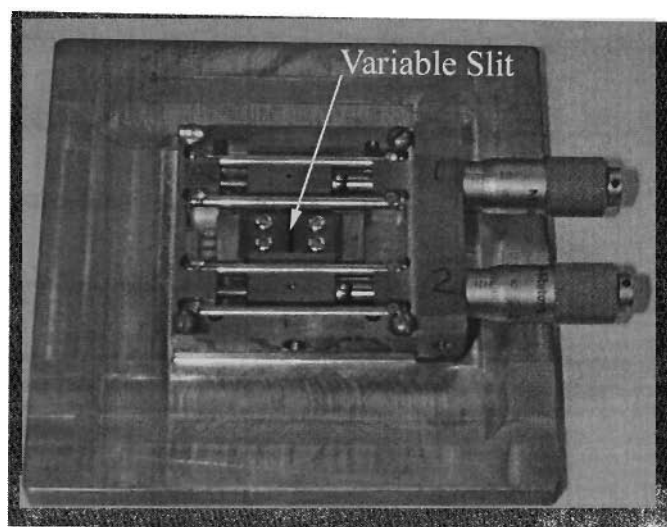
Variable slit-collimator for attaching to the applicator of a Therapax DXT300 orthovoltage x-ray machine
